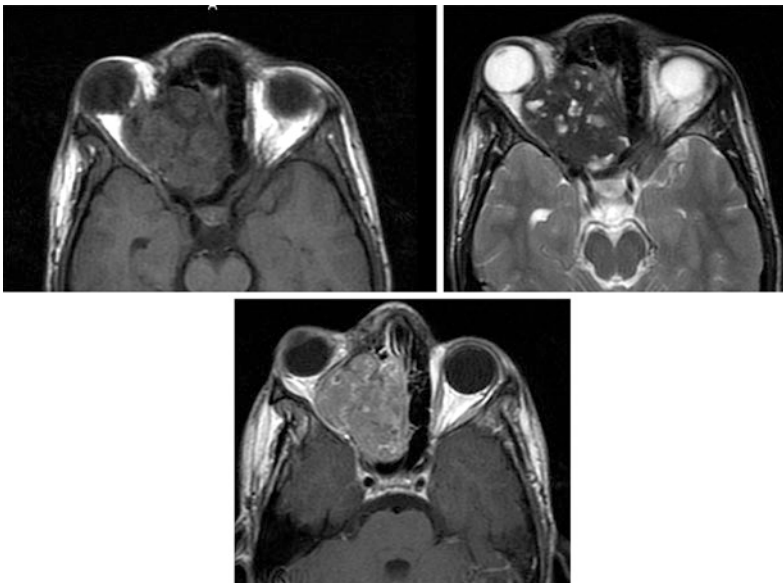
Fibrous dysplasia on MR imaging. a–c Axial T1WI, T2WI and post contrast T1WI MR images showing expansile lesion of the right ethmoid air cells with marked encroachment upon the orbital cavity. The lesion demonstrates isointense signal on T1WI (a), hypointense signal on T2WI with intra-lesional foci of high T2 signal due to cystic degeneration (b) and mild heterogeneous enhancement after contrast administration (c)
